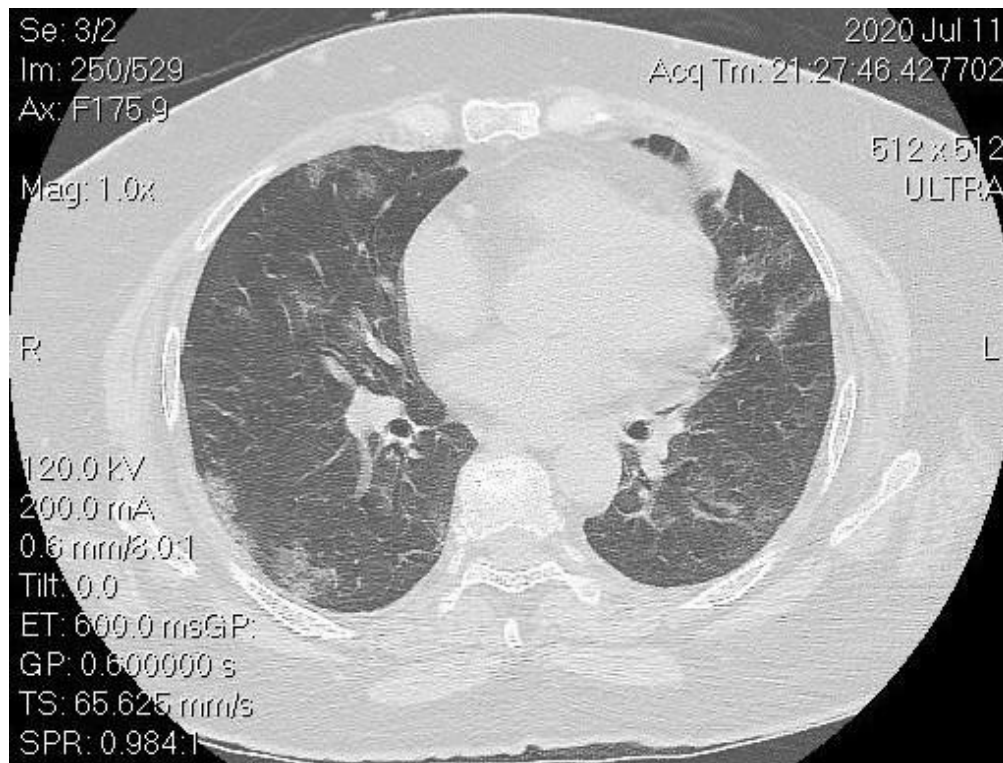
A high-resolution chest CT of a COVID-19 patient
